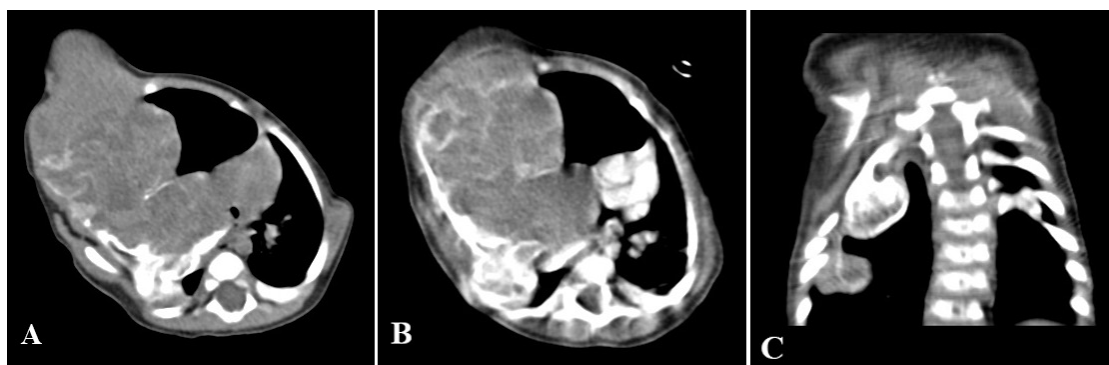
A) Axial CT-scan without contrast demonstrates a large lobulated mass containing several hemorrhagic cysts with calcified matrix and ossified septa. B) Axial CT with contrast demonstrates the large lobulated mass without significant enhancement. C) Coronal CT-section without contrast demonstrates bilateral involvement of the chest wall. Note the smaller mass with the same appearance medial to the eighth rib in right side
